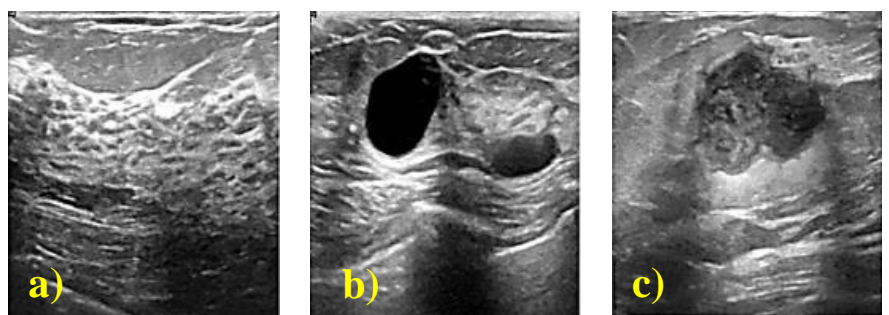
Samples of ultrasound breast image: a) Normal; b) Benign; c) Malignant [21]
